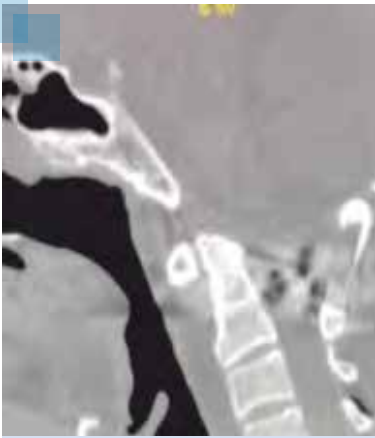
Post-operative CT CVJ showing reduced AAD
